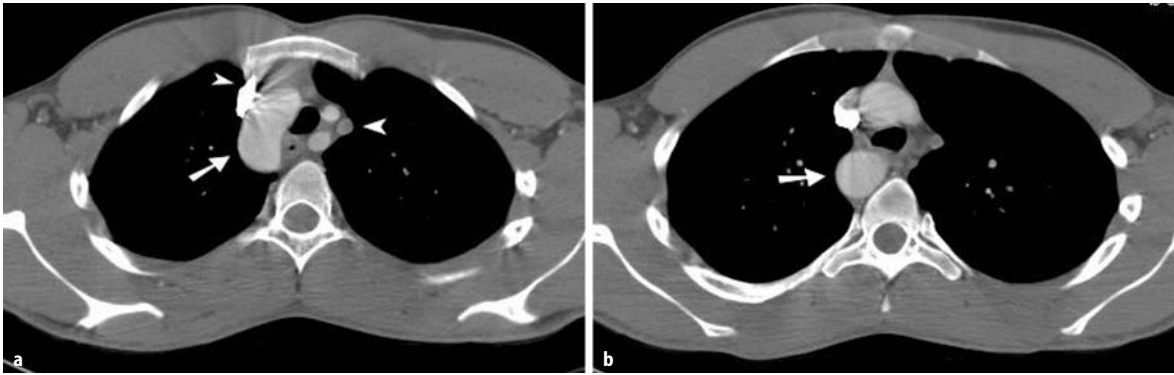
a Axial CT; right-sided aortic arch (*arrow*); note the presence of the double superior caval vein (*arrowheads*). b Axial CT at a lower level demonstrating the course of the descending thoracic aorta to the right side of the vertebral column (*arrow*)
